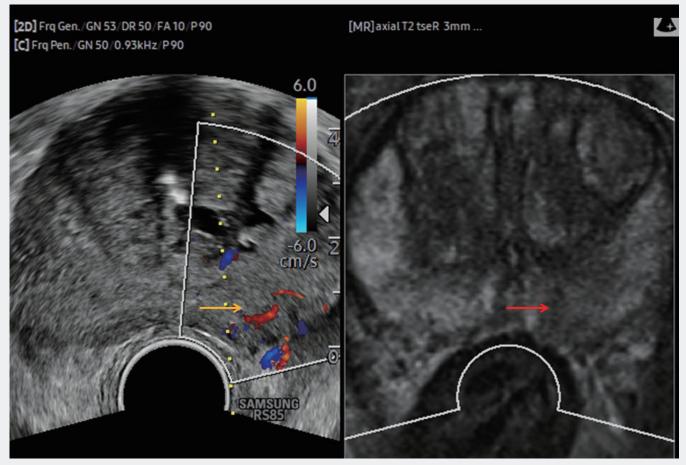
MRI-ultrasound fusion of the prostate. Color-coded duplex sonography shows the superficial lesion with increased vascularization (yellow arrow). The left T2-weighted MRI image shows a signal-lowered (hypointense) lesion suspected of being carcinomatous (red arrow).
